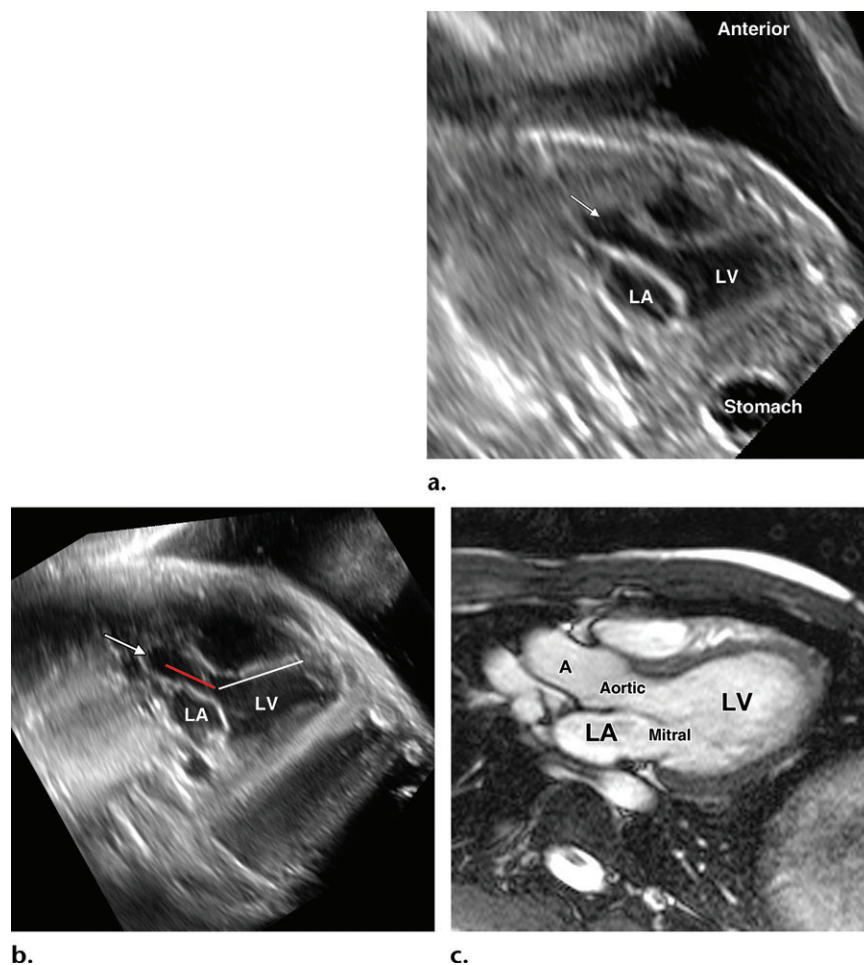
Images of LVOT in a fetus at 20 weeks gestation (a, b) and an adult cardiac patient (c). (a) Long-axis US view shows the vessel exiting the smooth-walled ventricular chamber. The left atrium (LA) and left ventricle (LV) are separated by the mitral valve, and the aorta (arrow) does not branch. Both the anterior and posterior walls of the aorta form distinct echogenic lines; any signal dropout is suspicious for a VSD. In real time, this view shows the fibrous continuity of the mitral and aortic valves. (b) In the same orientation, the ventricular wall (white line) creates an angle with the long axis of the aorta (red line). This angle is lost with the gooseneck aortic deformity seen when the aorta is "sprung" anteriorly in the setting of an atrioventricular septal defect. (c) LVOT view from adult cardiac MR imaging shows the same anatomy in a format that may be more familiar to radiologists. The mitral and aortic valve leaflets are visible. A = aorta, LA = left atrium, LV = left ventricle.
